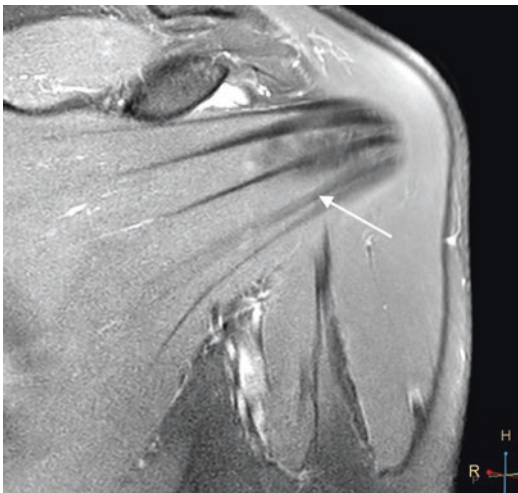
Subscapularis muscle tendinous cords in MRI imaging. White arrow indicates proper cord used for anterior wall augmentation
